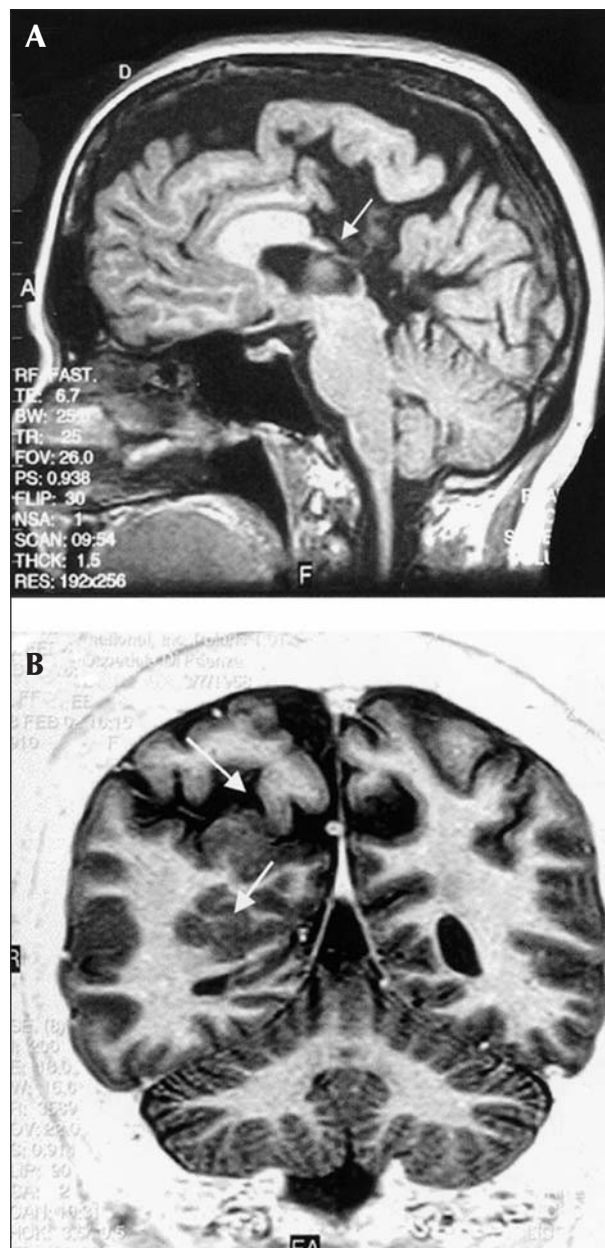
MR imaging in a patient with a complex cortical malformation. a) sagittal plane: partial agenesis of the corpus callosum that communicates with an interhemispheric CSF cyst (colpocephaly aspect); b) coronal plane: right temporal-parietal-occipital subcortical heterotopia with right fronto-temporal infolding.
